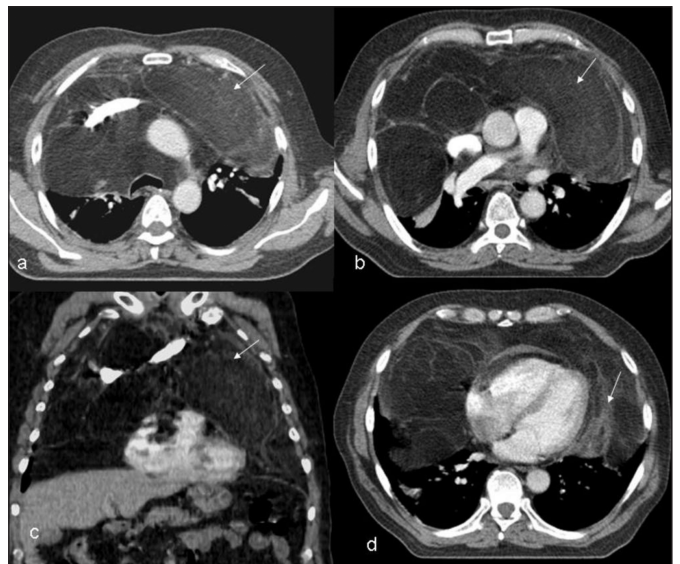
CT scan (axial a,b,d) and coronal (c) of a 44-year-old male patient shows a large, well-demarcated, inhomogeneous fatty mass with invasive features to the heart and vessels.
